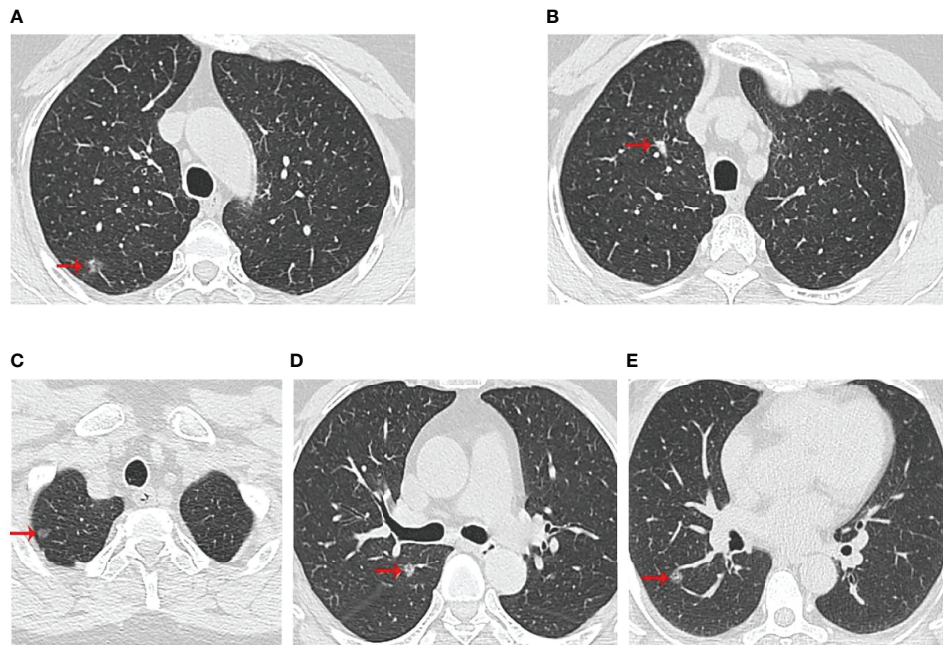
Computed tomographic scan of chest at diagnosis of three patients. (A, B) were II-2 CT scan results, which showed two nodules in the upper right lobe; (C, D) were II-4 CT scan results, which showed two nodules in the upper lobe of the right lung; (E) was II-5 CT scan results with a right lower lobe nodule. The red arrows indicated the location of the lesions.
